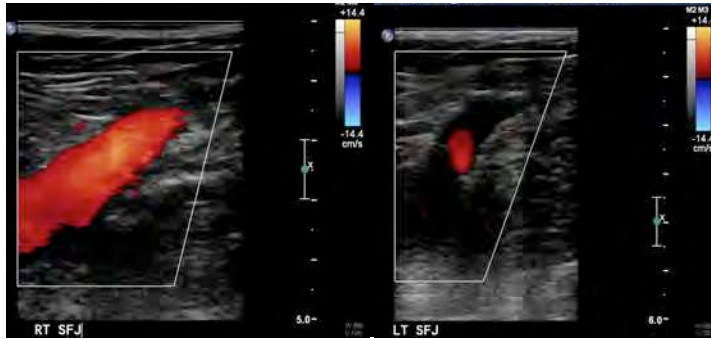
Bilateral SFJ reflux in a male patient who presented with long standing varicose veins, swelling and mild skin discoloration. He had no history of thrombosis and after detail imaging with ultrasound no signs of previous thrombosis were found. There is reflux in the right proximal common femoral vein in continuity with the SFJ. The common femoral vein distal to the SFJ is normal. As it is discussed in the text such deep vein reflux is abolished after eliminated the GSV reflux. On the left side there is reflux in the SFJ without affecting the common femoral vein.
